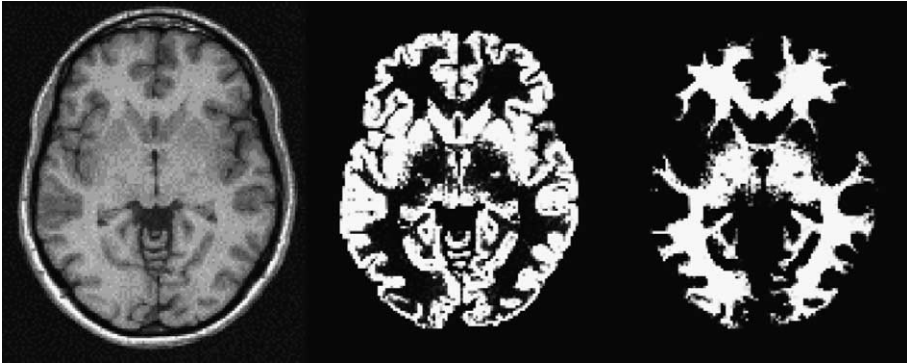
A representative axial MRI image (panel 1) together with the corresponding grey matter segment (panel 2) and white matter segments (panel 3).
